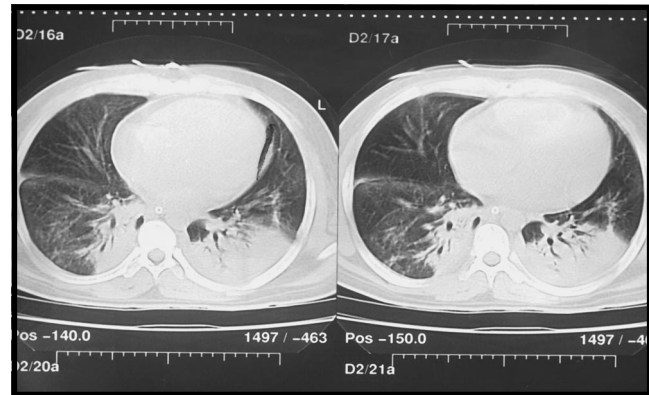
Computed tomography scan of the chest showed basal areas of consolidation and ground glass appearance.
